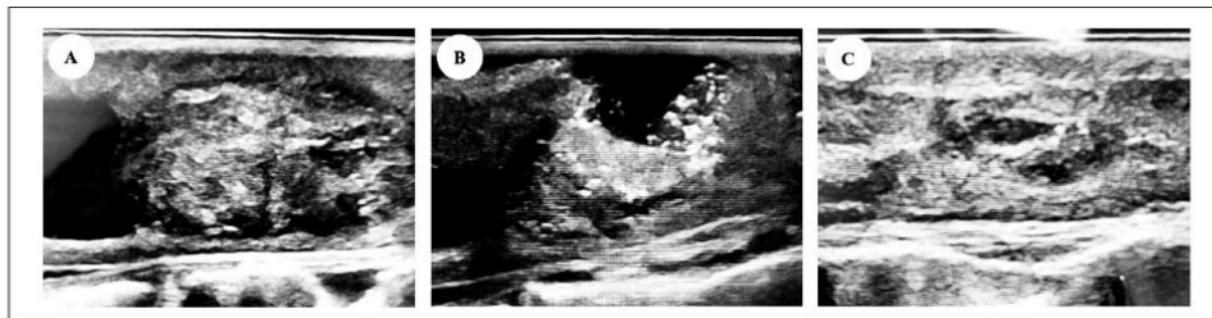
Case 1: Pre-removal (A), removal (B), and post-removal phase (C) intraoperative ultrasound images.
